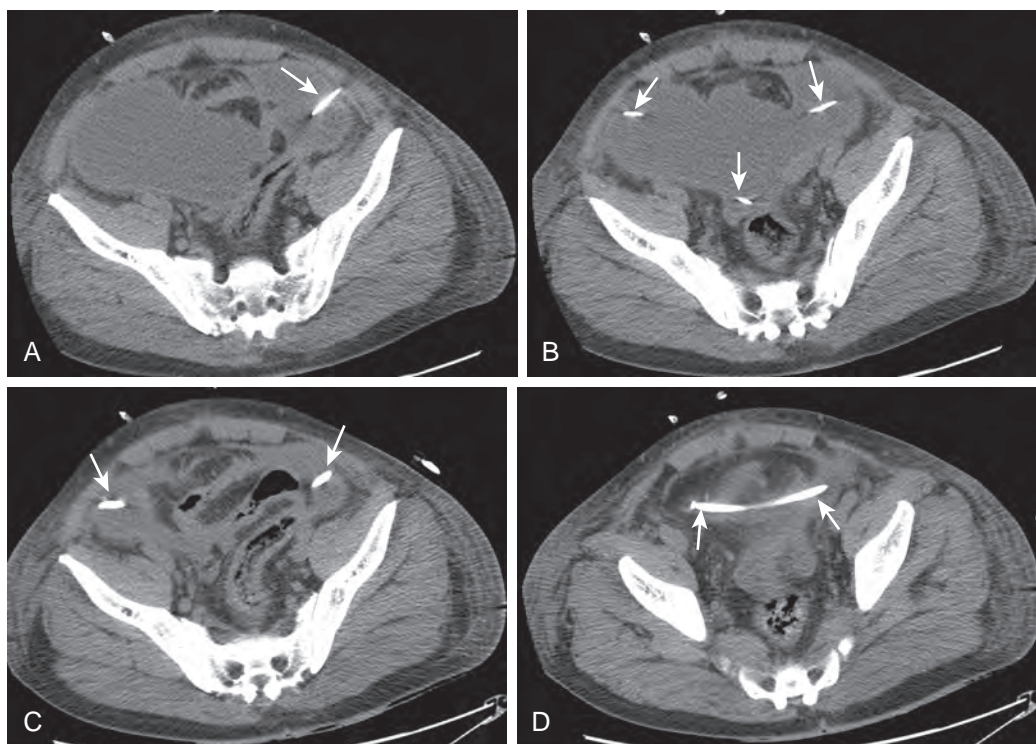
Seldinger technique for drainage of a large intraperitoneal abscess. A. Preliminary axial CT image shows the placement of an 18-gauge needle (arrow) into the intraperitoneal abscess. B. Subsequently, a guidewire (arrows) was introduced into the collection through the needle. C and D. After serial dilation over the guidewire, a 12F multi-side hole drainage catheter (arrows) was placed into the collection, resulting in adequate drainage.
